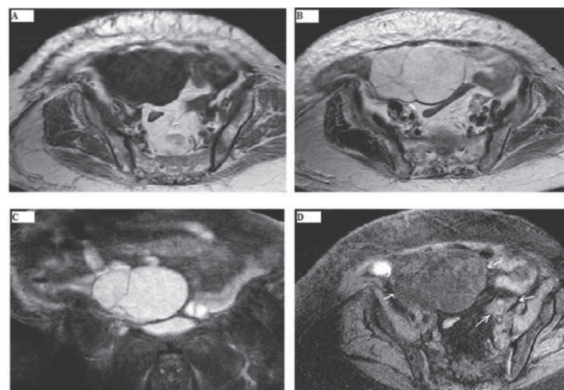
Magnetic resonance imaging shows right ovarian lesion to be a multilocular cyst; (A) homogeneous hypo; signal intensity on T1-weighted images and (B) high signal intensity on T2-weighted images. Left ovary has slight spiculations isointense on T1 and T2 weighed images. (C) T2 SPAIR axial image (D) with contrast material; T1-weighted WATS CE axial images show the presence of a slightly heterogeneous enhancement in the left ovary (right lower arrow).
